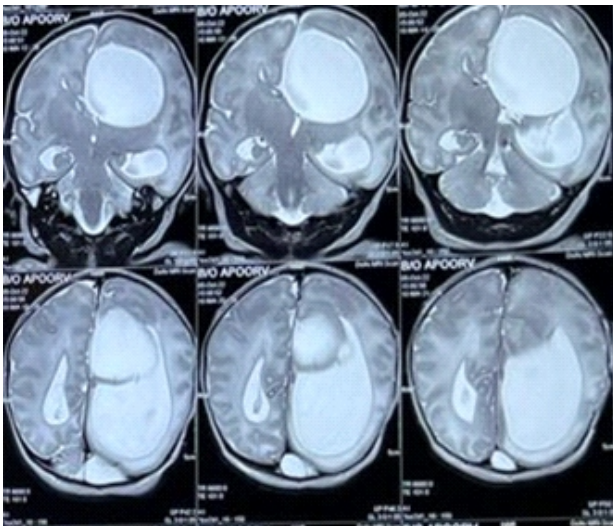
MRI Brain showing uniloculated interhemispheric cyst projecting to left of midline with dilatation of lateral ventricles
